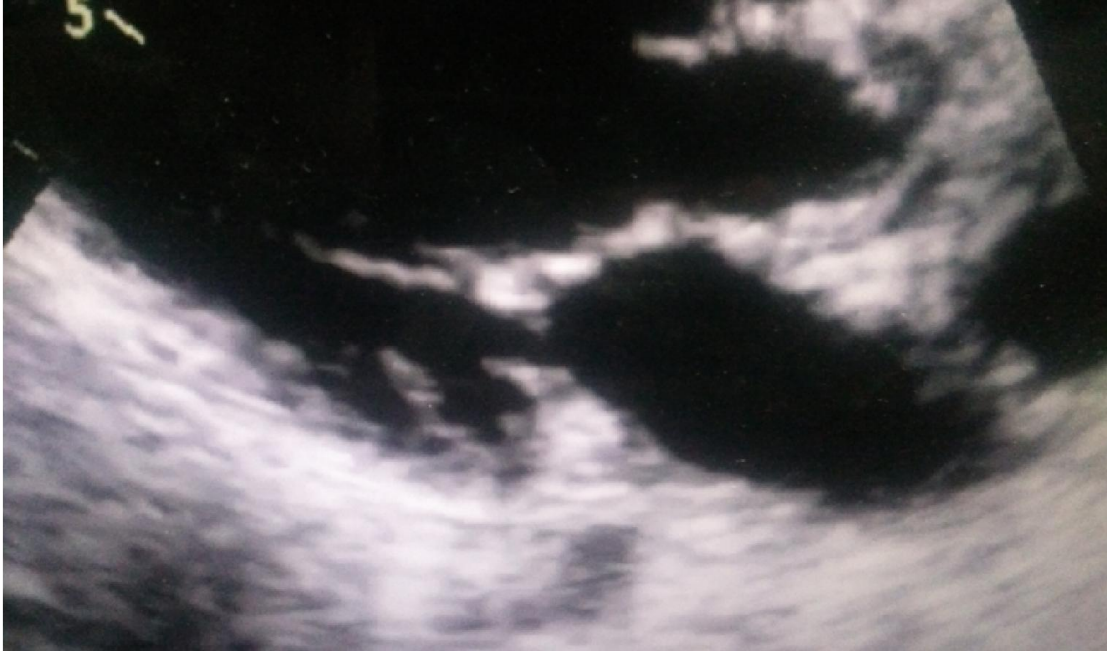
Long axis parasternal view showing clear LVOT after surgical excision of the obstructing membrane.
